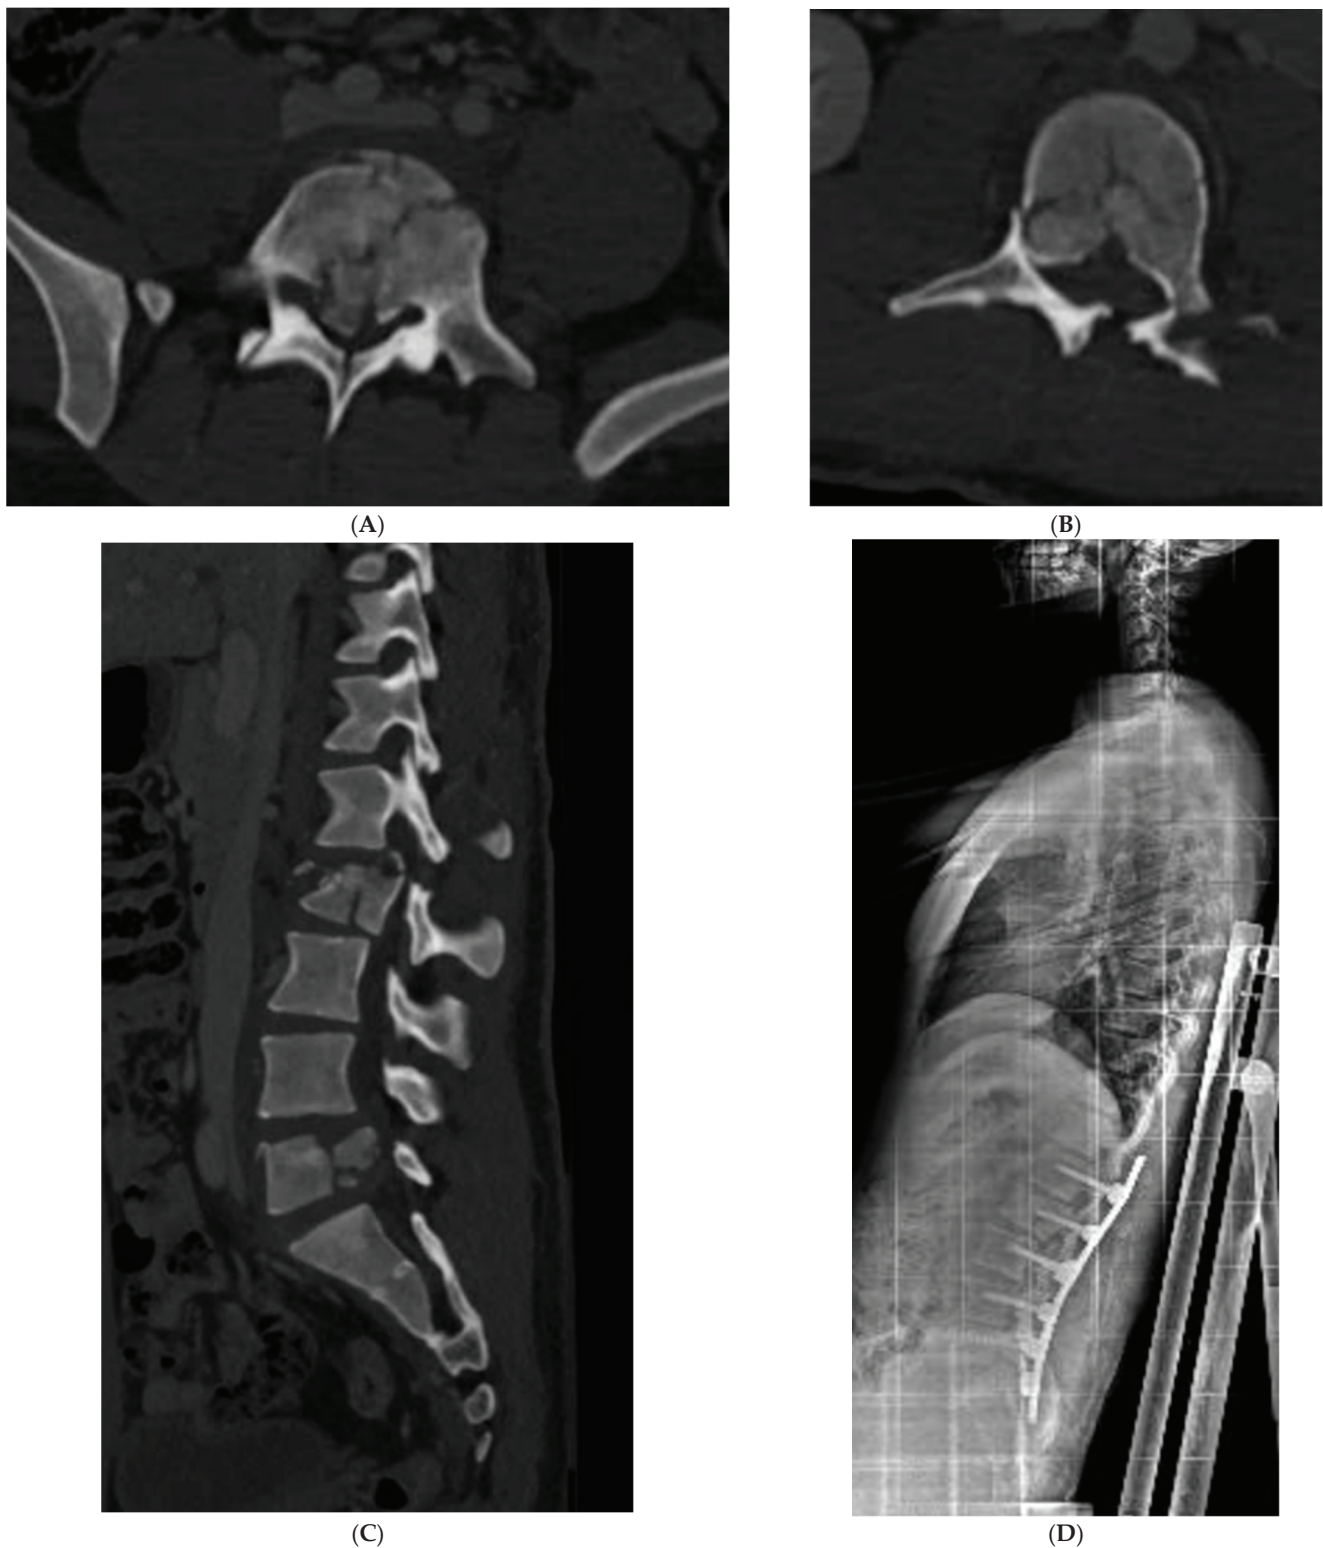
Case 10 (Table 1): (A) preoperative axial CT scan of L5; (B) preoperative axial CT scan of L2; (C) preoperative sagittal CT scan of lumbar spine; (D) postoperative X-ray lateral view in sitting position.
